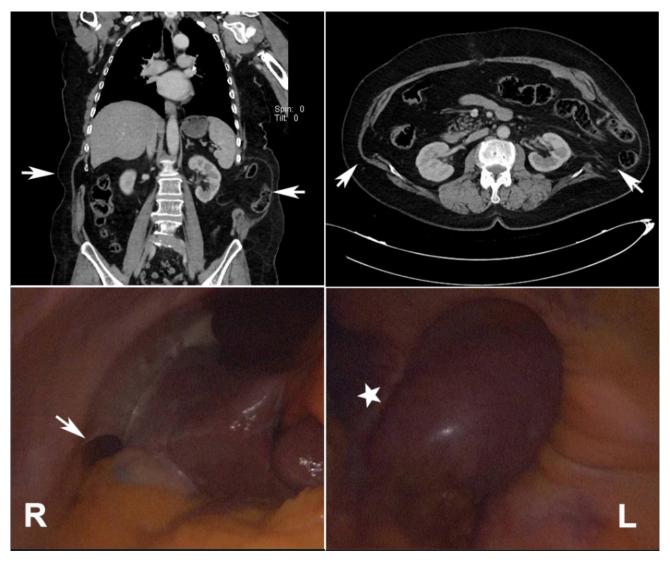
Computed tomography and intraoperative images of hernia defects. Abdominal computed tomography of axial and coronal sections (top row) showing bilateral hernias (arrows) that are large on the left side and extended until the 12th costa at the bottom and small on the right side. Laparoscopy imaging (bottom row) showing hernia defects on the right side (star) (R) and left side (arrow) (L).
